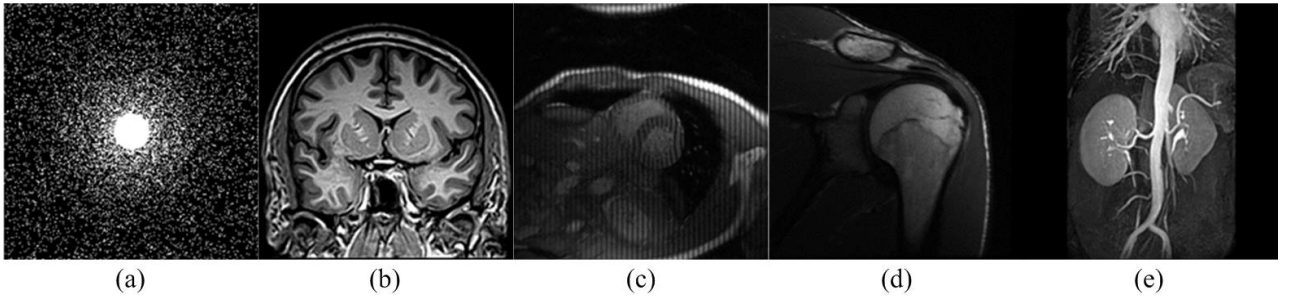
k-space undersampling mask and MR images. (a) k-space sampling mask, (b) Coronal brain, (c) Cardiac, (d) Shoulder, (e) Renal arteries.
